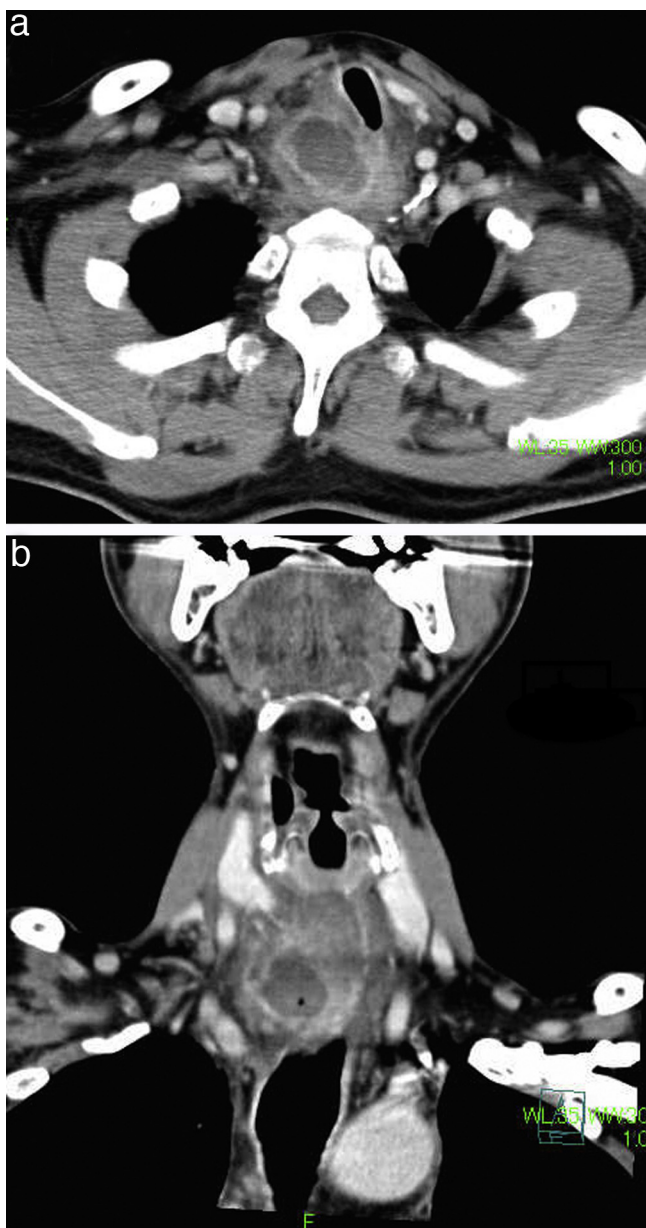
An enhanced CT scan demonstrating the trachea displaced by a paratracheal mass with a well-defined thin wall (a: axial view, b: coronal view).
